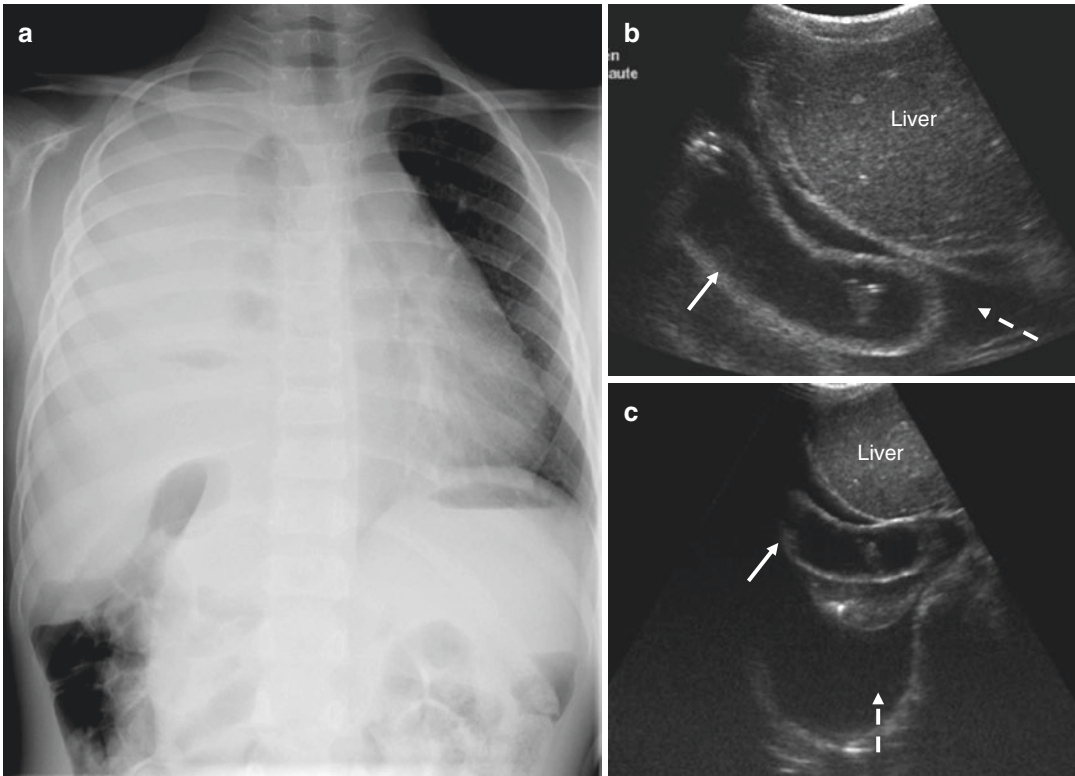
Strangulated traumatic diaphragmatic hernia in a 4-year-old boy after a fight at school. On examination, the child complained of abdominal pain and vomiting and at first, US and abdominal radiograph were normal. After 12 h, the child developed respiratory distress. (a) Chest
